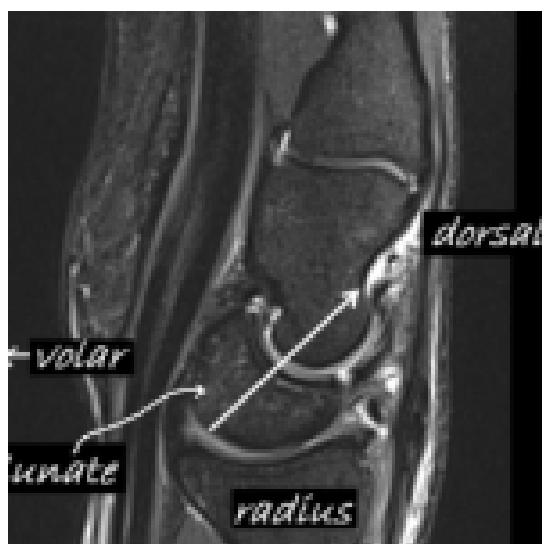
Lateral view of the wrist on MRI, showing the lunate extended, i.e. tilted towards the dorsal surface. (Some have suggested that this looks like a tea cup that has been tipped over.) This "tilted tea cup" is indicative of complete disruption of the scapholunate ligament.
